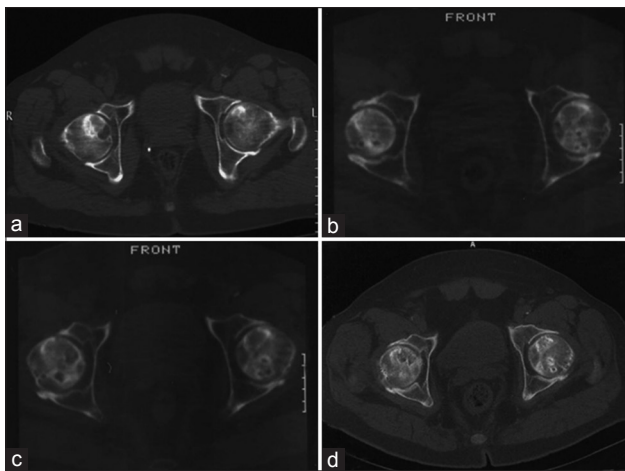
Images of a 49-year-old male: (a) A preoperative CT image showed AVNFH in bilateral femoral head; (b) CT image is 22 months after the surgery showed there were not obvious deteriorate AVNFH compared with the preoperative CT; (c and d) CT image is respectively 49 months and 96 months after the surgery showed obvious deteriorate AVNFH compared with the preoperative CT, but there were not collapsed. AVNFH: Avascular necrosis of femoral head; CT: Computed tomography.
